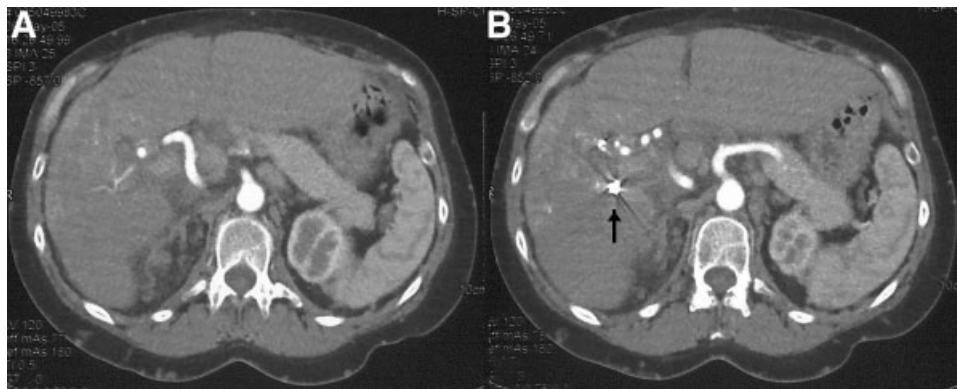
Abdominal computed tomography after selective coil embolization of the arterioportal fistula, showing the disappearance of the portal vein opacification (A), and the presence of the coils (black arrow B).
